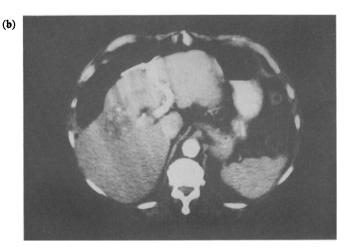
(a) Patient number 16: initial dynamic CT. Heterogenous postcontrast enhancement of a large hypervascularised hepatocellular carcinoma, with compression of the bile ducts, but without thrombosis of the portal vein. (b) Patient number 16: dynamic CT 6 months after treatment. Clear modifications of this tumour with intense decrease in size, hypodense aspect, and regression of the biliary ducts dilatation.
